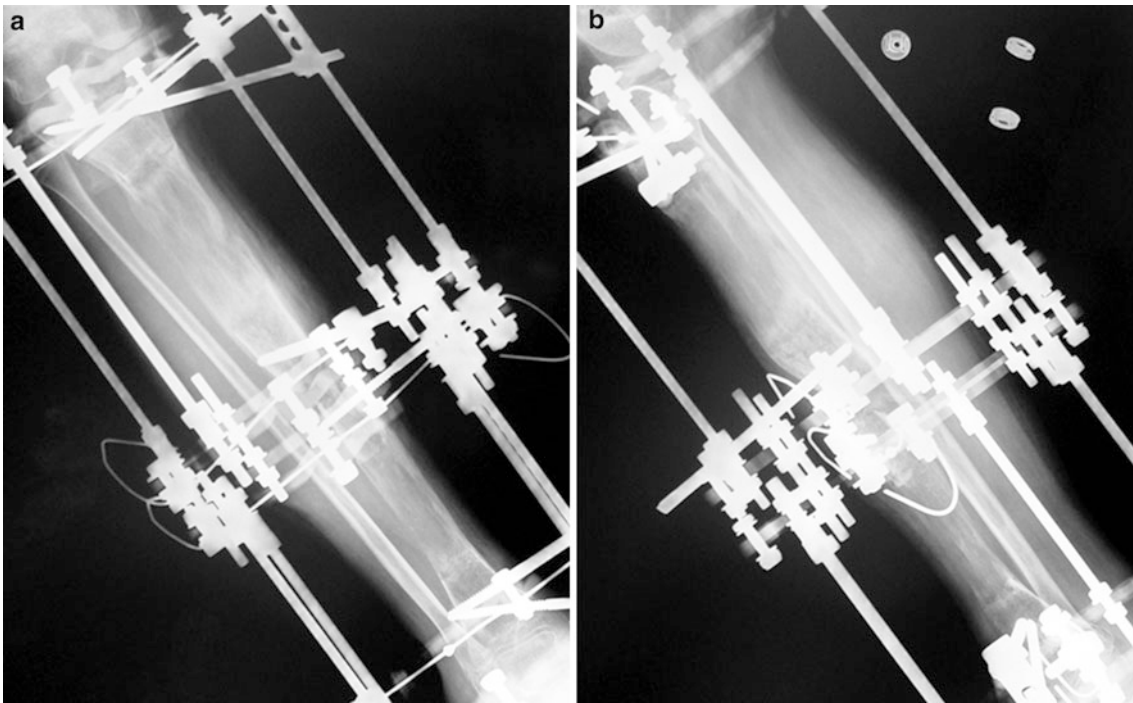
Two-level osteotomy for transport performed with a high-quality regenerate. Proximal and distal segments are being compressed to achieve union. AP (a) and Lat (b) radiographs
